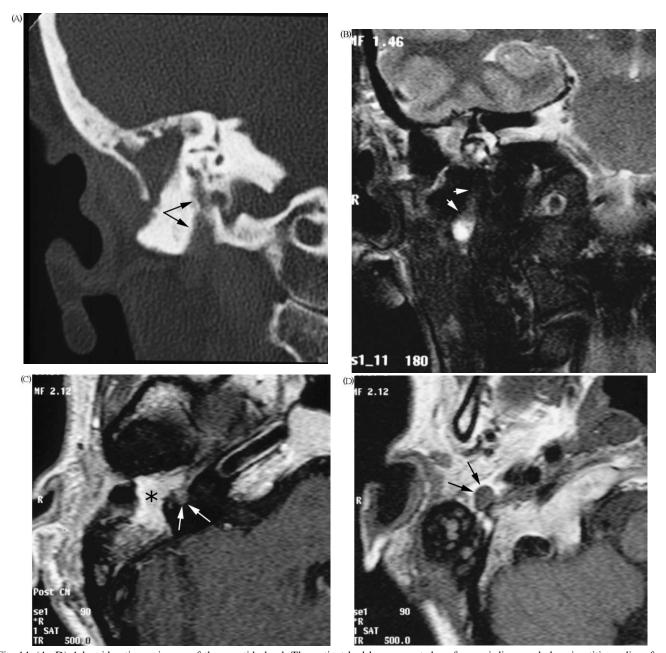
(A–D) Adenoidcystic carcinoma of the parotid gland. The patient had been operated on for a misdiagnosed chronic otitis media a few months before. Enlargement of the stylomastoid foramen and of the third portion of facial nerve (arrows) with unsharp margins is demonstrated at CT (A). MR obtained 2 months after CT shows hyperintensity (B) and enhancement (C and D) of an enlarged facial nerve (arrows) suggesting perineural spread. Enhancing granulation tissue (asterisk) is demonstrated by MR (C) in the middle ear cleft.
